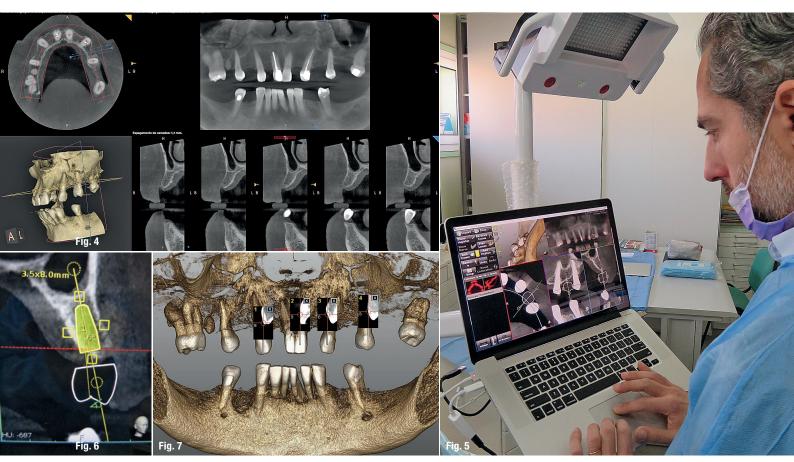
CBCT image made using a standard protocol (without radiographic marker). Fig. 5: Prosthetic implant plan using the Navident software. Fig. 6: Modified implant plan with six-degree vestibular angulation. Fig. 7: Navident trace registration user interface.
